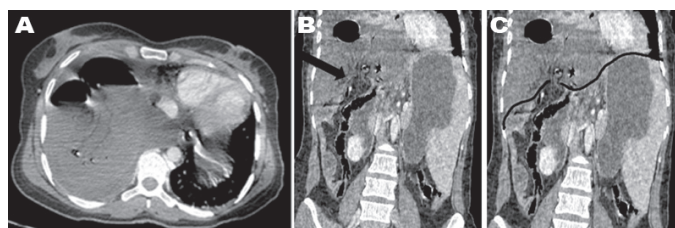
Iodine enhanced thoracic & abdominal CT-scan (A) Axial slice showing the herniated intestinal loops in the right hemi-thorax, with pleural effusion and compression of the mediastinum. The herniated loops are very mildly enhanced if none at all and located against the posterior ribs which represent the “fallen sign”. (B) Direct discontinuity of the right diaphragm with the “collar sign” [black bold arrow]. (C) The diaphragm is highlighted in black for better visualization of the discontinuity.
